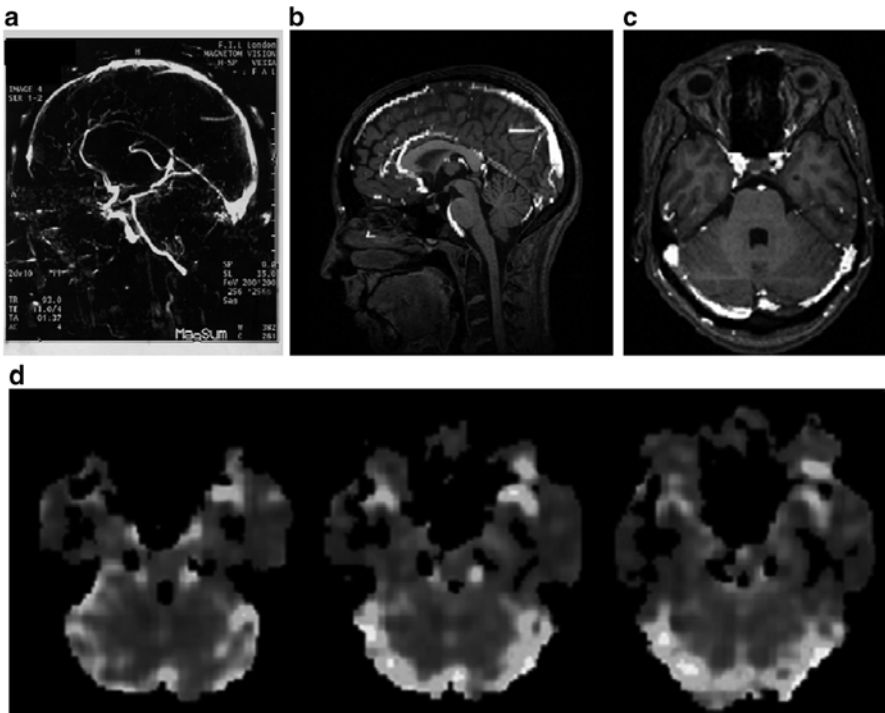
Influence of large veins on inhomogeneities in the regional cerebrovascular response to hypercapnia. MRI angiography of venous vessels (a) has been superimposed upon anatomical (T1 weighted) MRI section of (b) the whole brain in sagittal section and (c) the cerebellum in transverse section. (d) Magnitude of BOLD signal change in response to hypercapnia in three contiguous sagittal sections of the cerebellum anatomically close to the section in (c). Increasing signal change is indicated in an arbitrary scale from grey to white. Note that the areas of greatest signal change in response to hypercapnia are anatomically similar to the location of large veins
